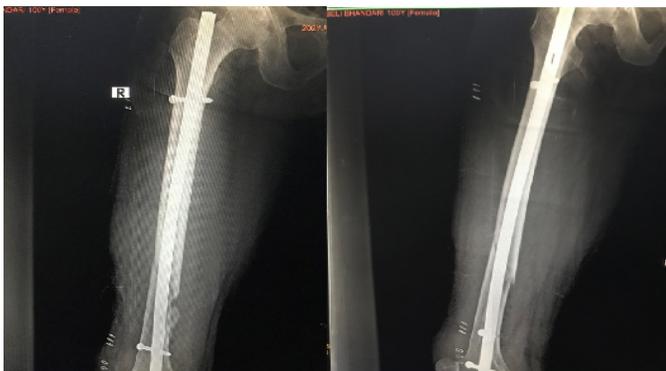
Postoperative AP and Lateral X-ray of femur after fixation with intramedullary nail
